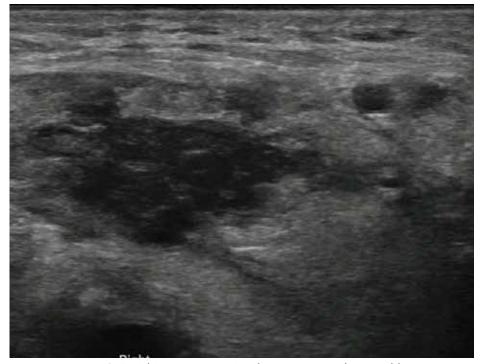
Bedside ultrasound showing lymph node irregularities
